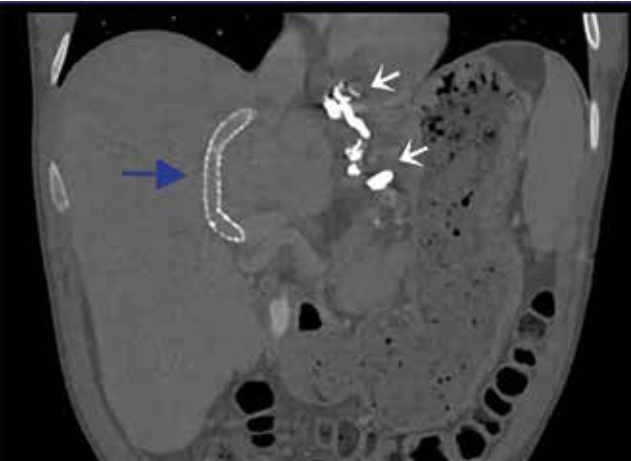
Post procedural coronal CT image demonstrates TIPS in place (blue arrow) with lipiodol: nBCA glue cast filling the gastroesophageal variceal complex (white arrows)
